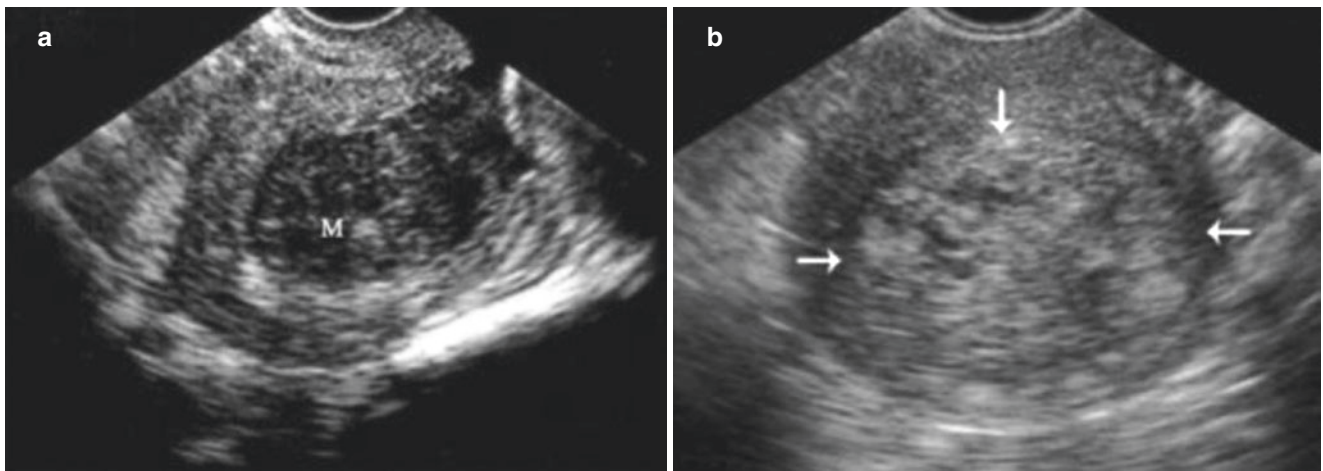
Differential diagnosis of leiomyoma and intrauterine remainder. (a) A hypoechoic subserosal fibroid with a distinct boundary. (b) Seven days after a drug-induced abortion. Sonogram shows a heterogeneous hyperechoic mass in the uterus of a patient with vaginal bleeding. The arrow indicates the intrauterine residual
